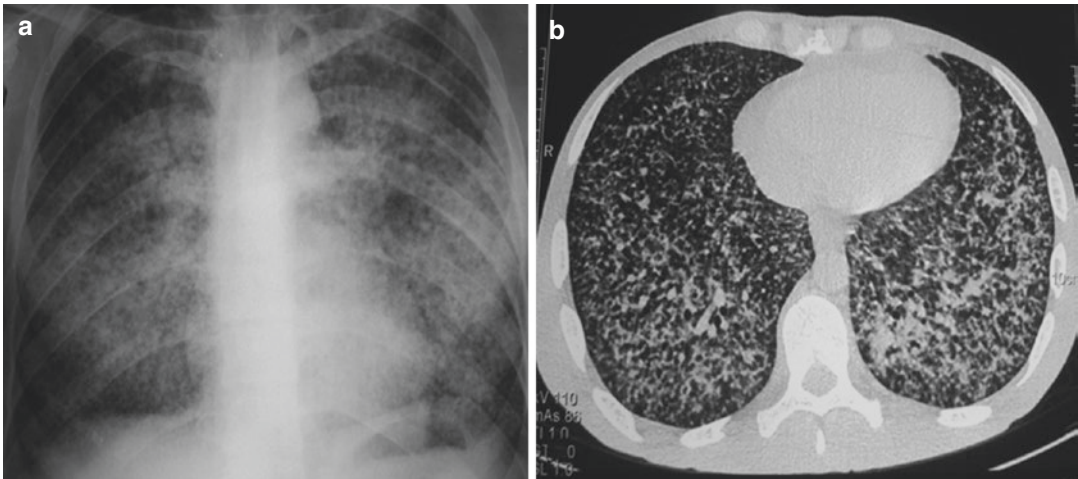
Miliary tuberculosis (TB). Frontal chest radiograph (a) shows bilateral diffuse fine tiny nodules. Axial high-resolution chest CT scan (b) demonstrates innumerable randomly distributed fine discrete nodules bilaterally.
